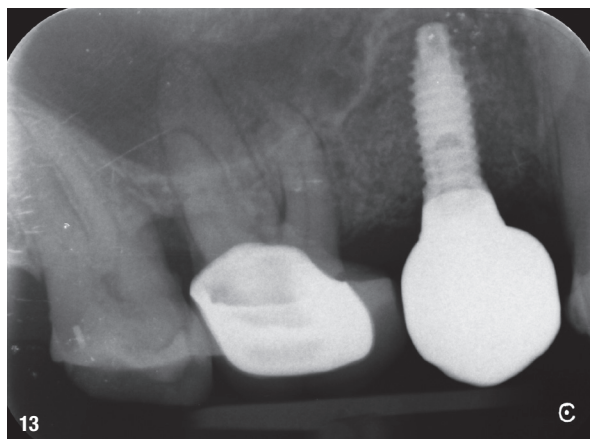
Post-op periapical radiograph showing the screw-retained implant crown seated.
